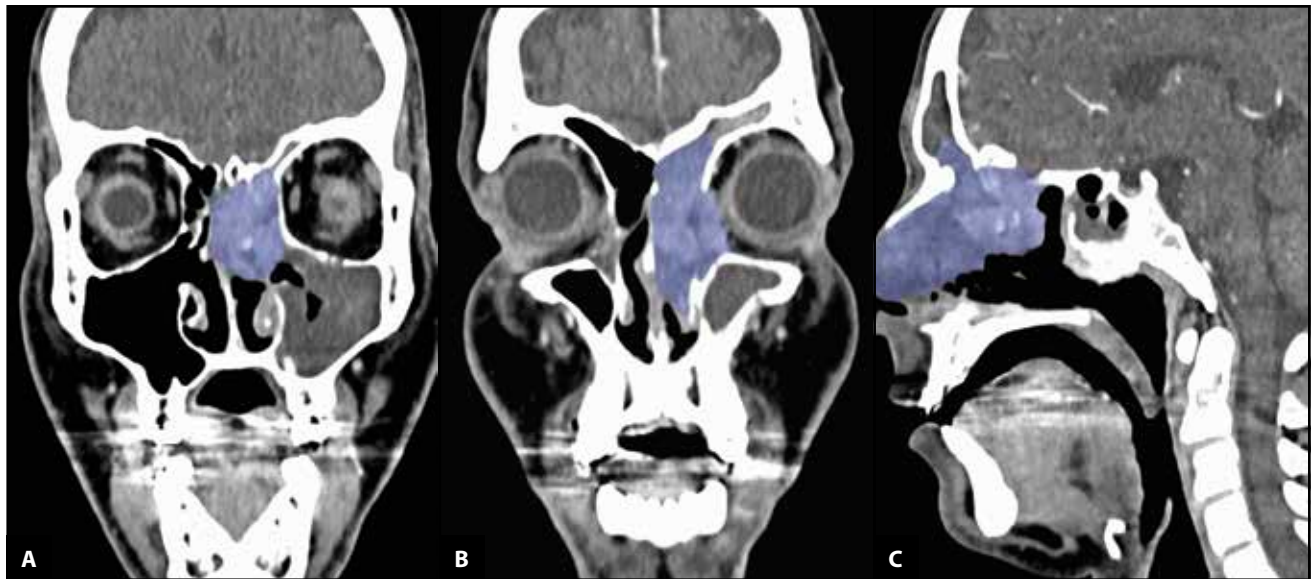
Cranio-facial CT images showing the tumour (purple highlight) in coronal (images A, B) and sagittal (image C) incidences.
